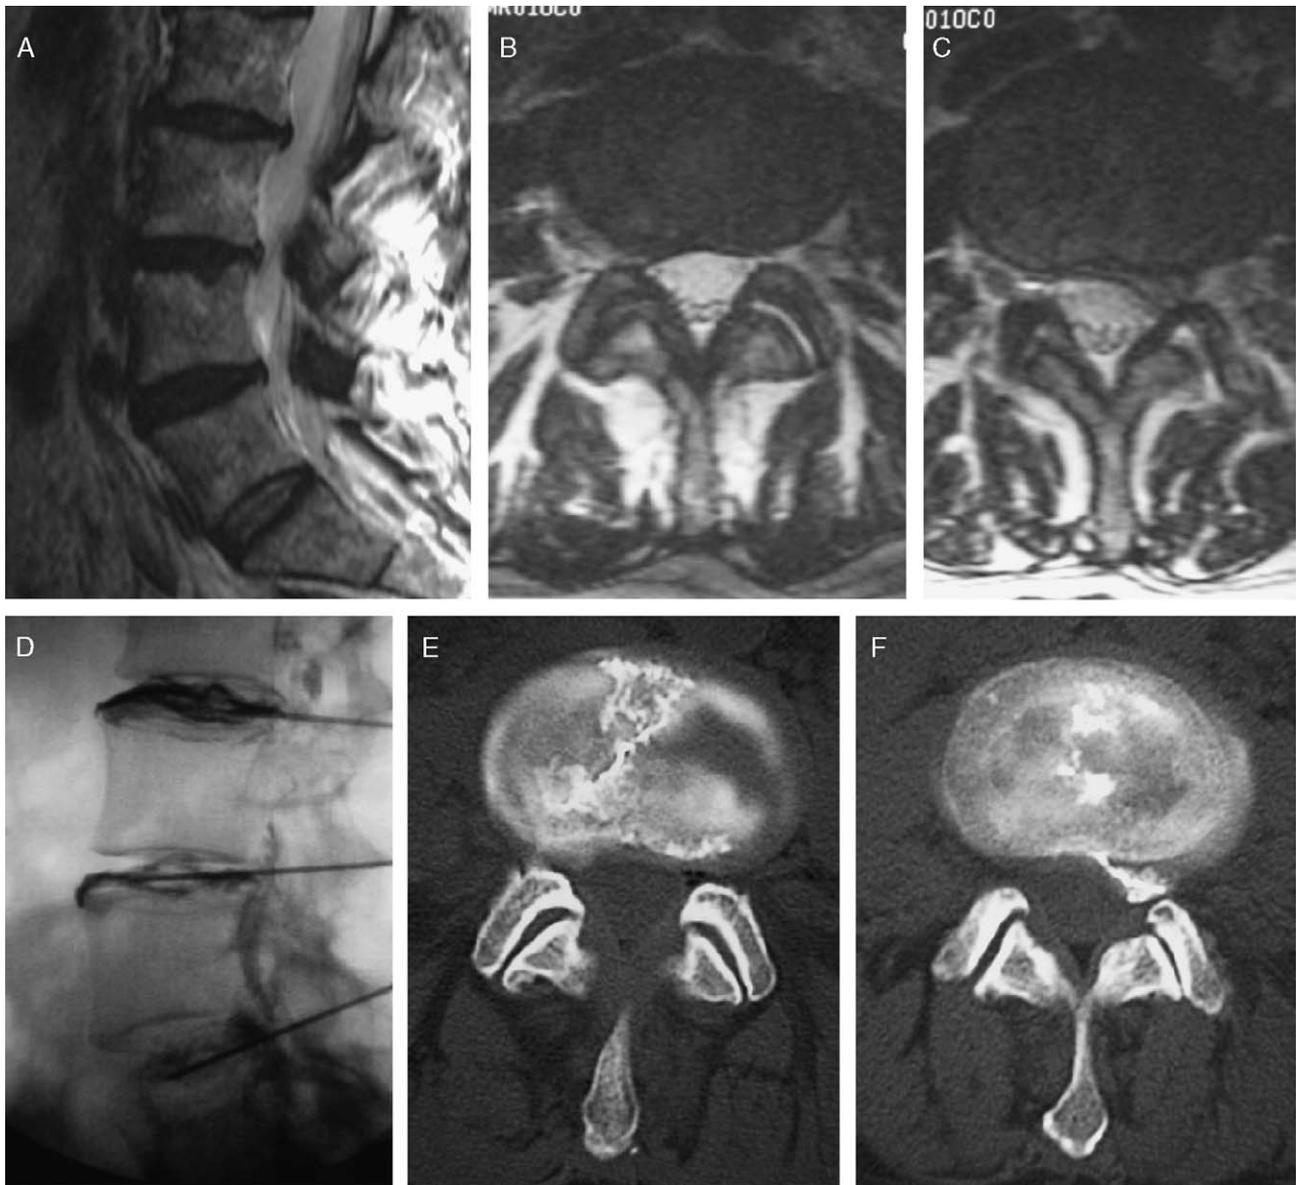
A 53-year-old woman who presented an invalidating lumbago for 1 year, stopping her from working. After the treatment of symptomatic levels at discography with good clinical result, the patient returned to work. A, Lumbar MR imaging. Several minimal disk bulges are demonstrated on the sagittal sequence. B, L2/L3 CT, minimal right foraminal bulging. C, L3/L4 CT, left foraminal bulging. D, Discography of the last 3 lumbar disks. The 3 disks are degenerated. An epidural leak is visualized at the L3/L4 level. A pain is only demonstrated at contrast injection of L2 /L3 and L3/L4 disk levels. An injection of RGE is achieved in L2/L3 and in L3/L4. E, Disco-CT posttreatment, L2/L3 disk level. RGE is demonstrated in intradiscal fissures oriented toward and in the right disk bulging. F, Disco-CT posttreatment, L3/L4 disk level. RGE is demonstrated in intradiscal fissures oriented toward and in the left disk bulging.
